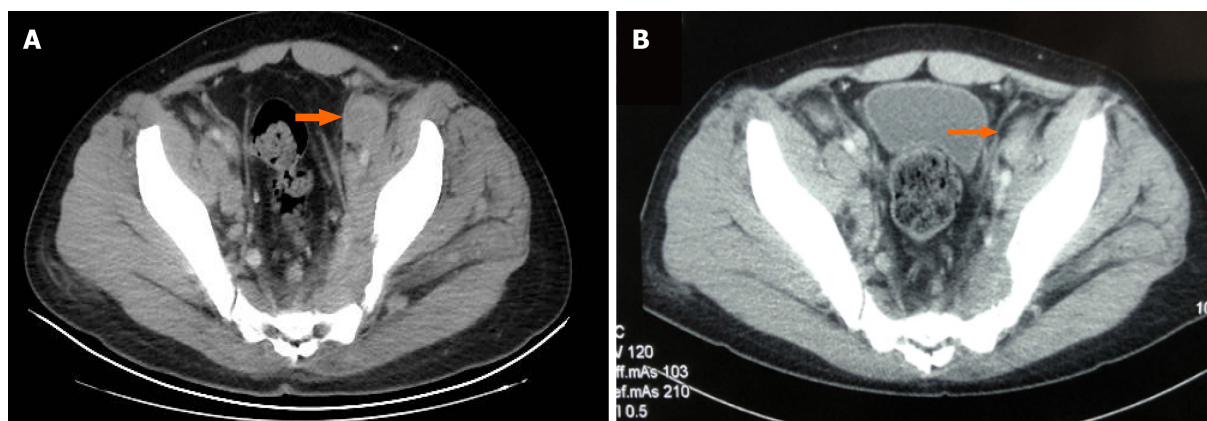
Computed tomography scan of the abdomen and pelvis before and after combination therapy. A: Imaging features before treatment; B: Imaging changes after three cycles of treatment.
